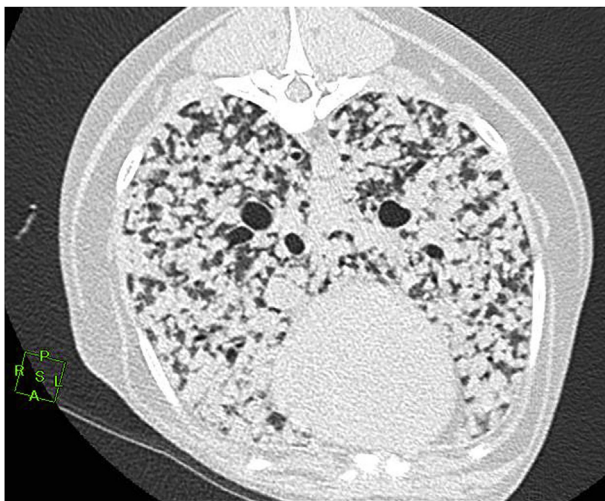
Computed tomography of the thoracic cavity reveals multiple nodules measuring 2–5 mm in diameter in both lungs.
